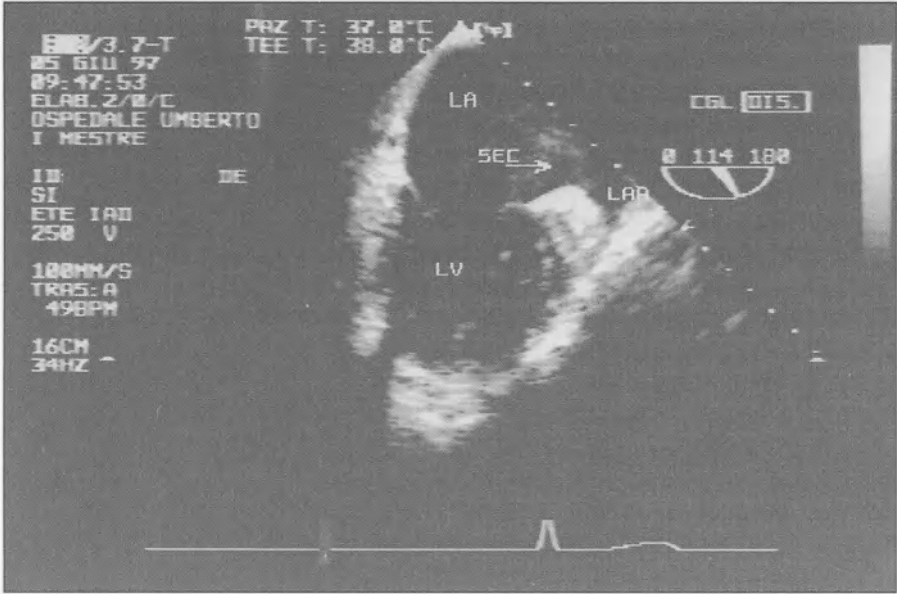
Transesophageal echocardiographic approach of left atrium (LA), of left ventricle (LV) and of left atrial appendage (LAA): the spontaneous echocontrast (SEC) increased just after an effective shock with restoration of sinus rhythm is clearly visualized
